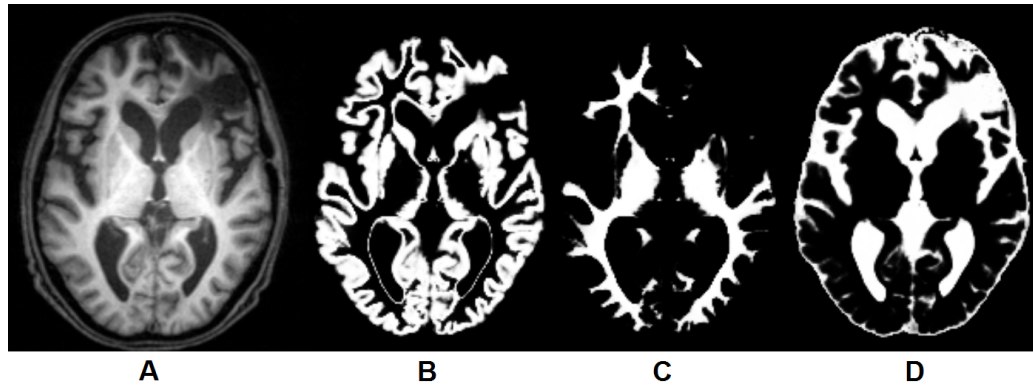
Research results obtained using unified segmentation: patient MRI scan slice (A), grey matter TPM (B), white matter TPM (C) and CSF TPM (D)
